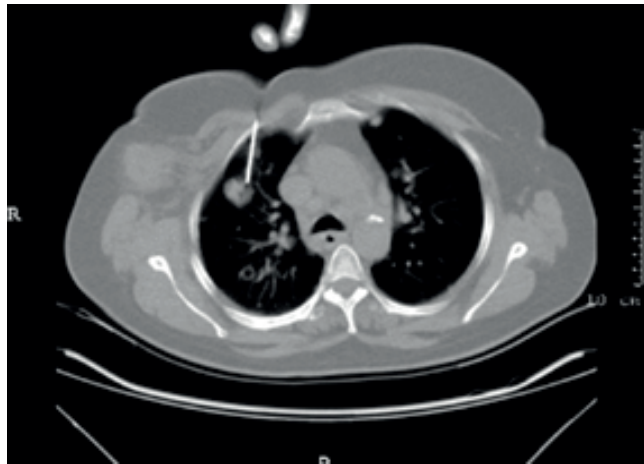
CT-guided Percutaneous core needle biopsy
